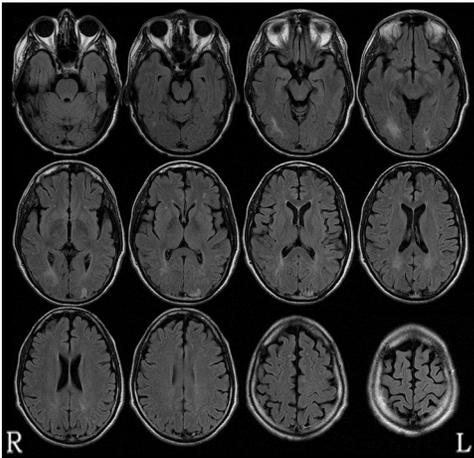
MRI scans of patient KC
